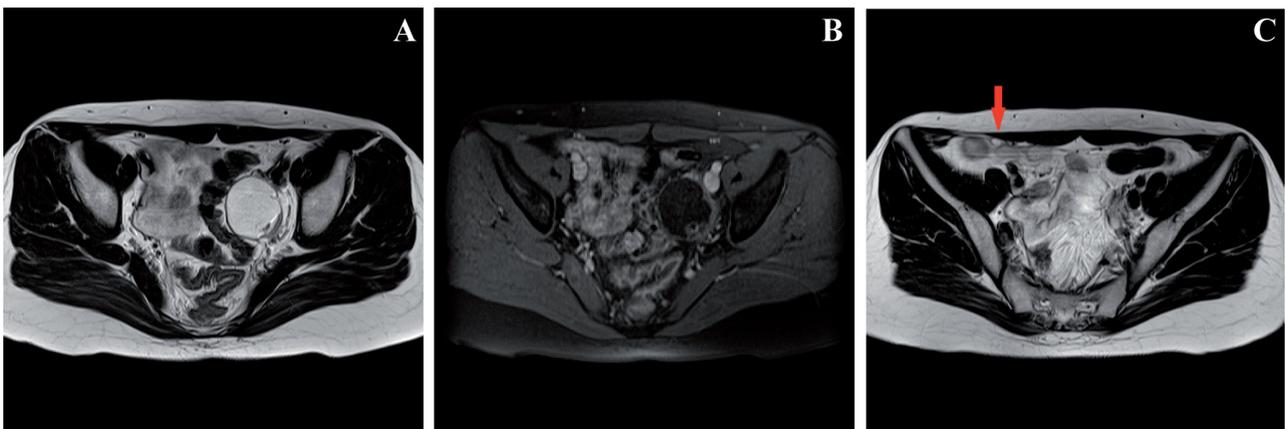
A: MRI showing a multiple cystic mass within the left adnexa. B: T2 weighted axial MRI images low. Fat suppression within the left adnexal mass. C: T2 weighted axial MRI demonstrating the peritoneal mass.
